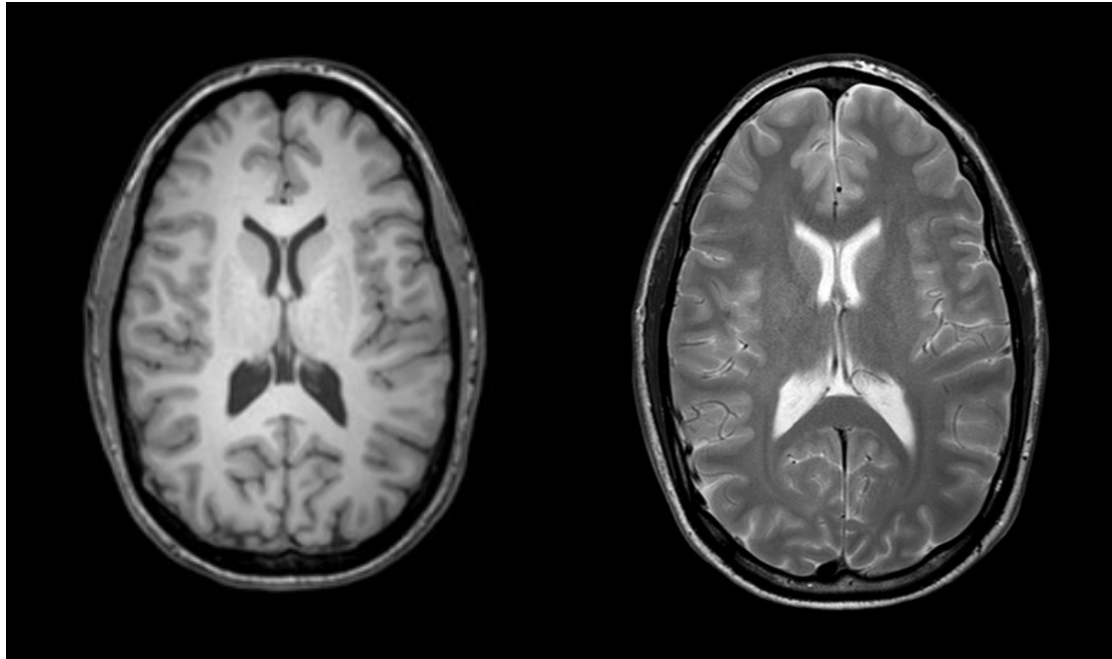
MRI axial images of a healthy brain
